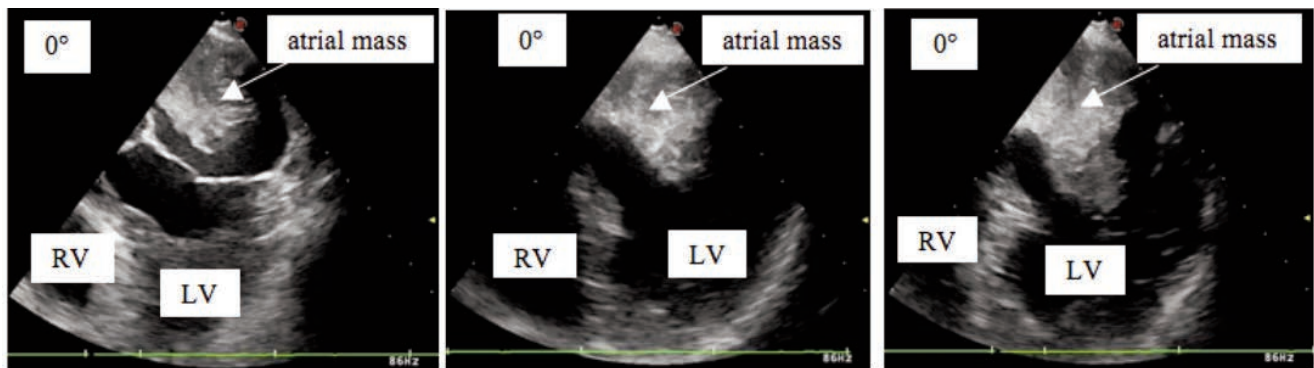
Transesophageal ecocardiography, showing a peduncolate disomogeneous mass occupying the entire left atrium, with the extremities until the mitral valve plane (on dyastolic and systolic left atrium contraction). RV, right ventricle; LV, left ventricle.
